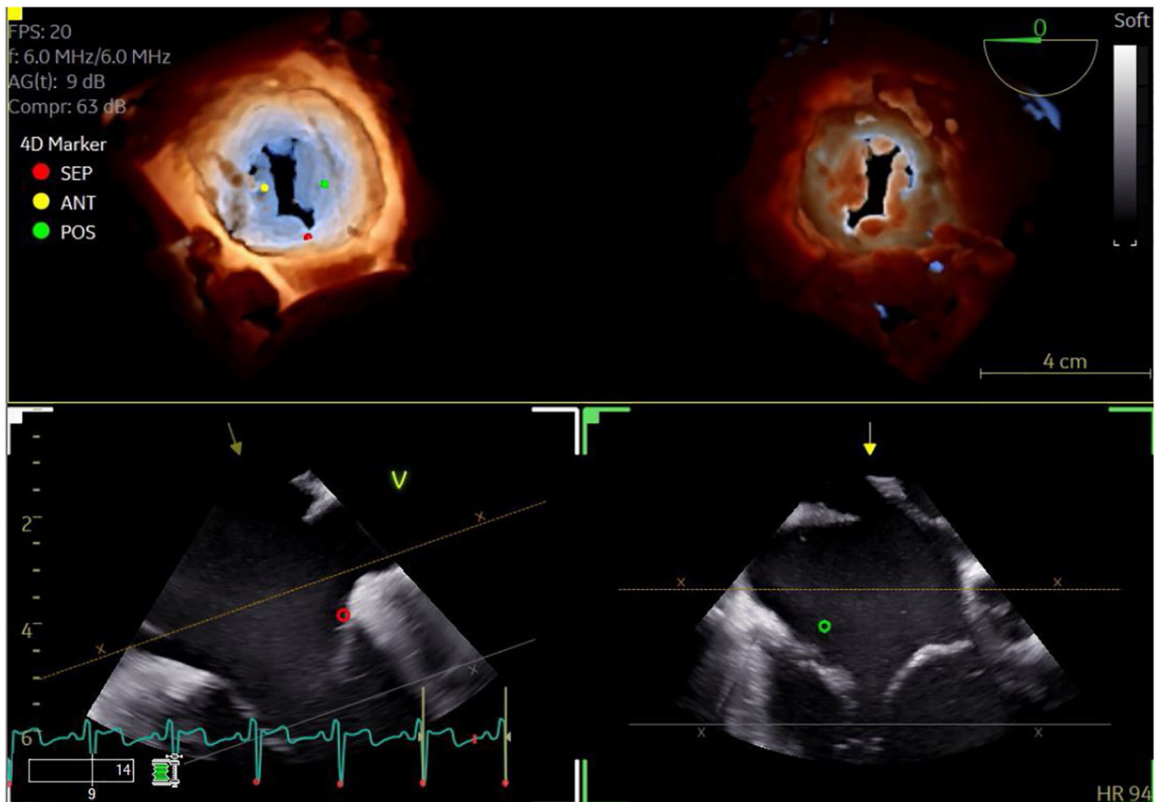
3D Transesophageal Echocardiography of the Tricuspid Valve With Transillumination
